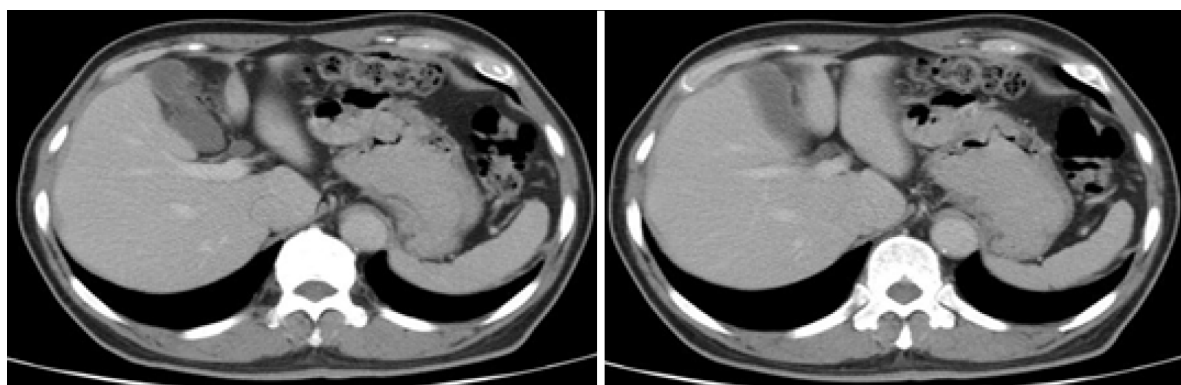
Pre-treatment abdominal contrast-enhanced computed tomography images. These reveal thickening of the stomach wall above the gastrojejunostomy site without enlarged perigastric lymph nodes. There is no evidence of lesion extension into the serosa or surrounding soft tissues.
